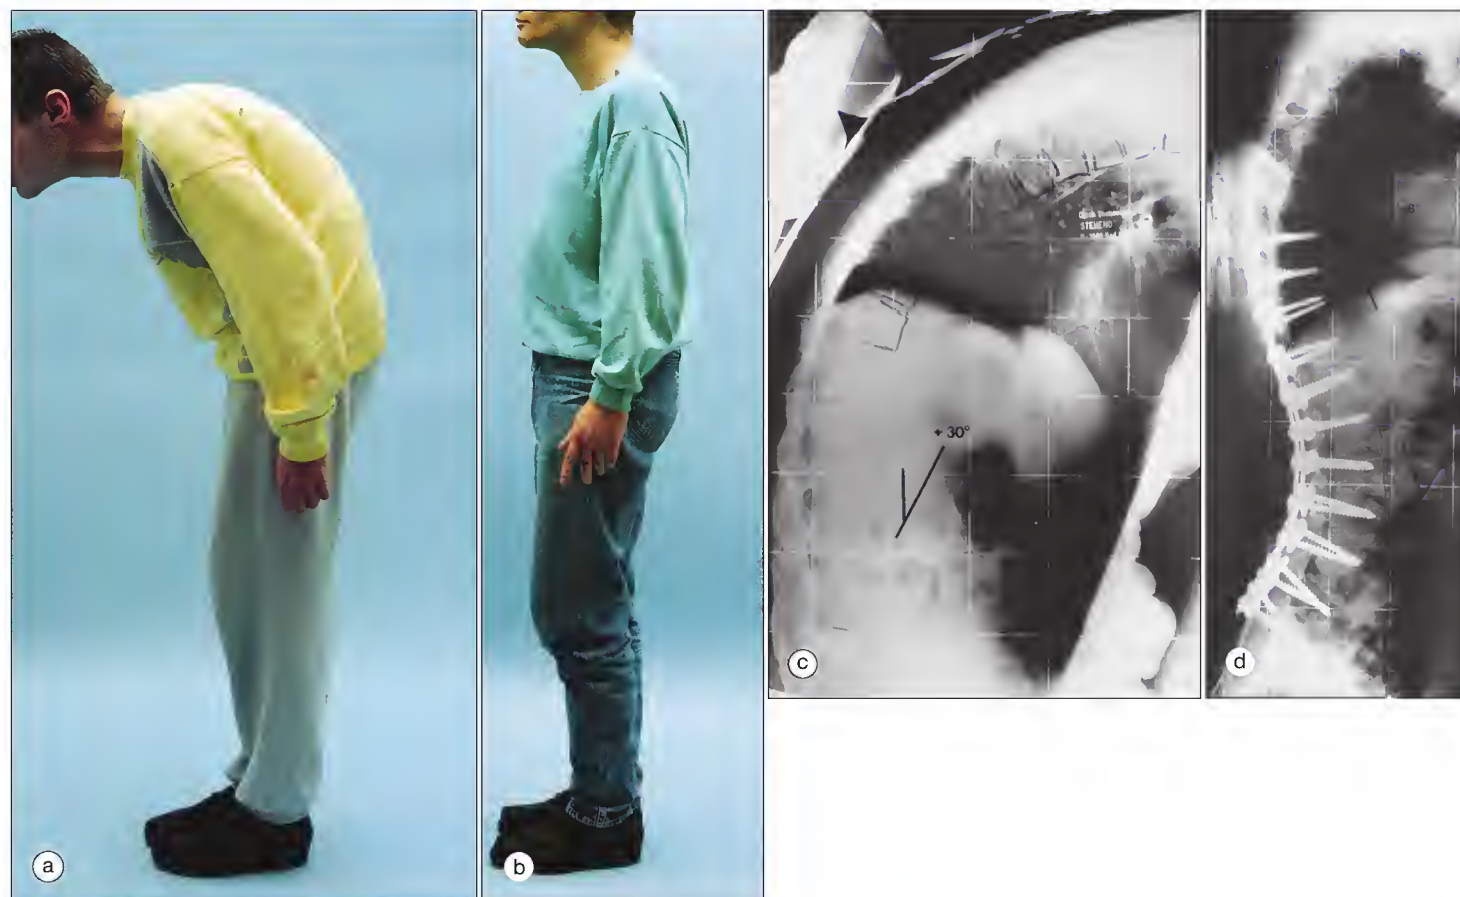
Patient with ankylosing spondylitis before (a) and after (b) correction of severe kyphosis by polysegmental wedge osteotomy. Radiographs before (c) and after (d) correction are shown. (Courtesy P. Metz-Stavenhagen, Bad Wildungen, Germany.)
